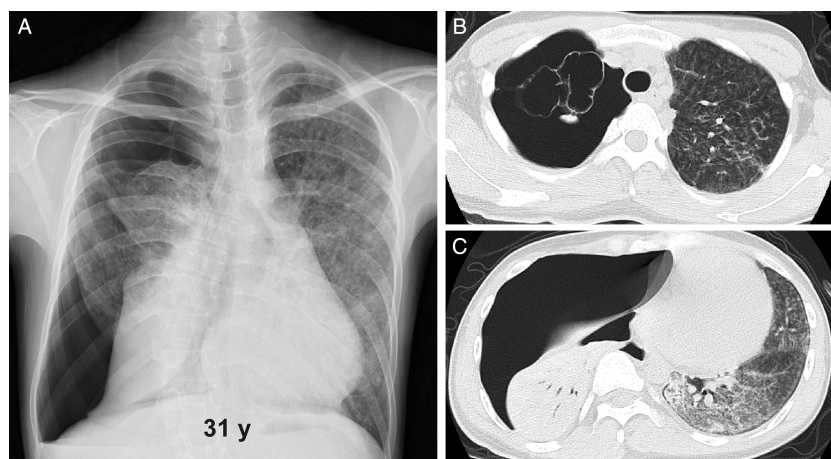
Chest images on admission at 31 years. (A) A chest radiograph showing pneumothorax on the right side. (B, C) Chest computed tomography images showing subpleural cysts at the apex of the right lung and worse diffuse ground-glass opacities of the left lower lobe.
